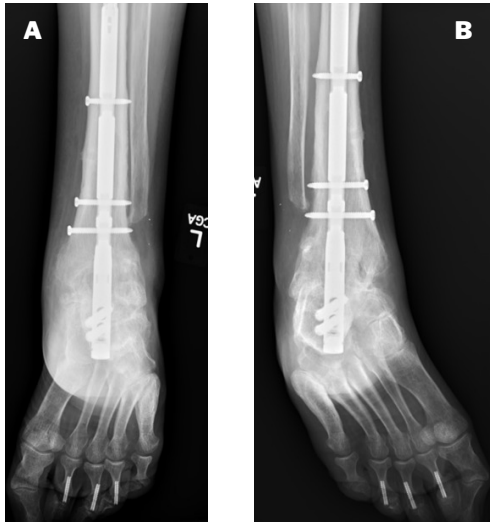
Figure (A-E): Three WB ankle radiographs 1 year post op showing maturing signs of fusion across the ankle and subtalar joints and union of the tibial osteotomy. A. AP view B. Mortise view C. Lateral view D. AP Tib-Fib view including the ankle E. Lateral Tib-Fib view including the ankle
